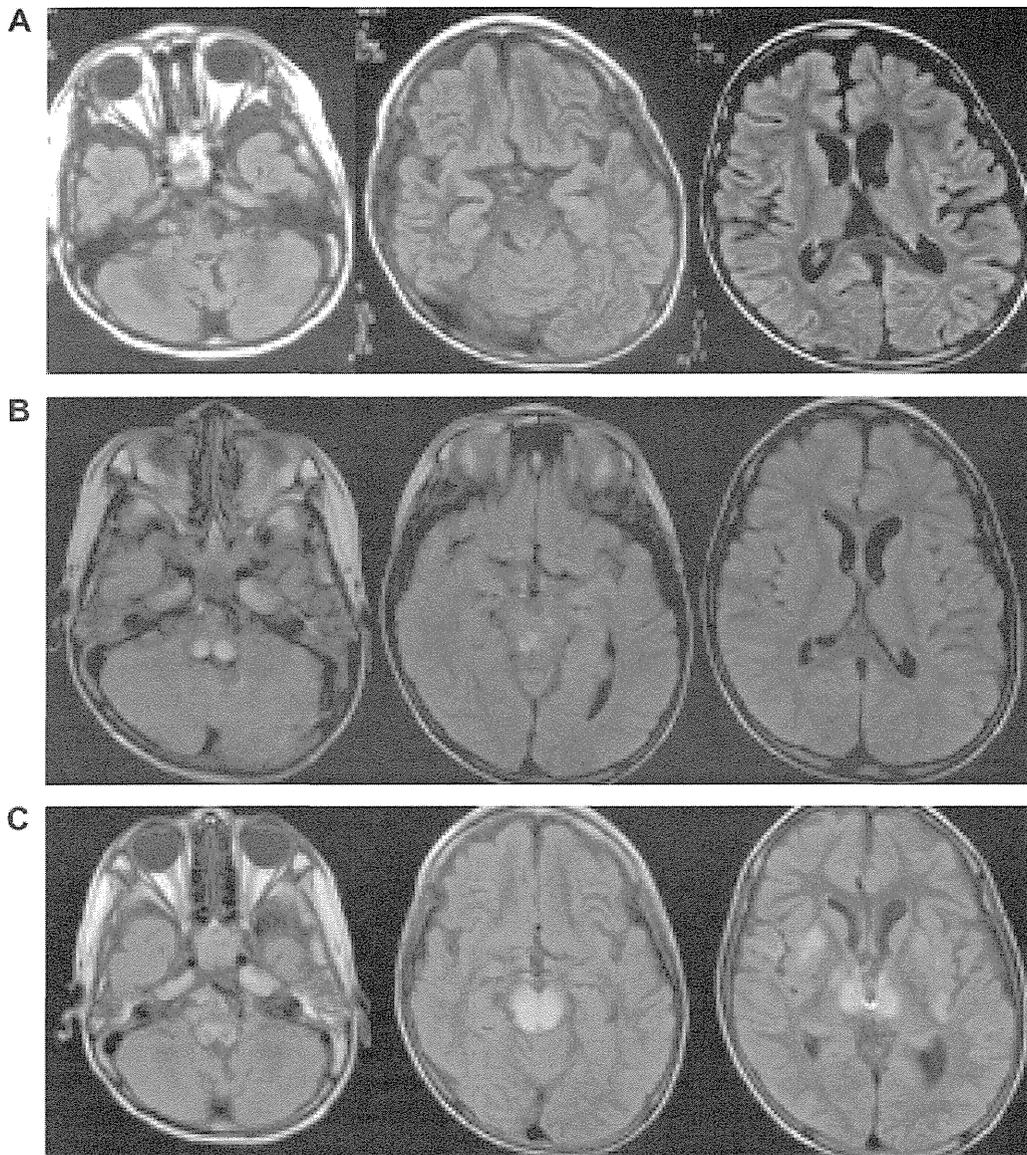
Brain MRI (FLAIR images) (A) At 4 years of age, when MERRF was diagnosed: diffuse cerebral cortex atrophy. (B) At 6 years of age, when LS was diagnosed: Bilateral, symmetric, high-intensity lesions are seen in the brainstem from the pons to medulla. (C) Six weeks after diagnosis: the lesions extend to the thalamus and bilateral cerebral hemispheres.
